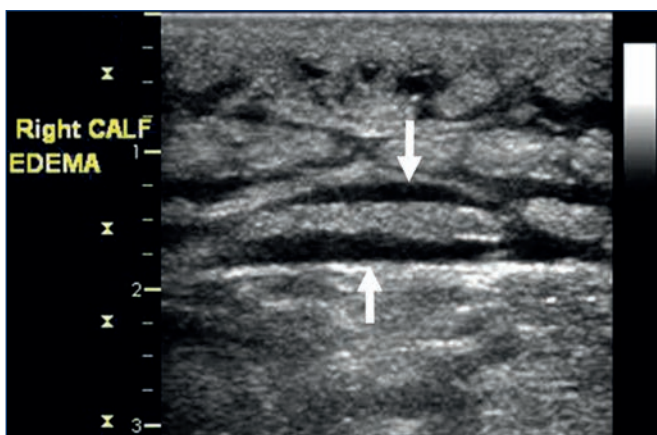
Longitudinal ultrasound image demonstrating horizontally-oriented echo-free spaces (arrows) suggesting more severe edema.
